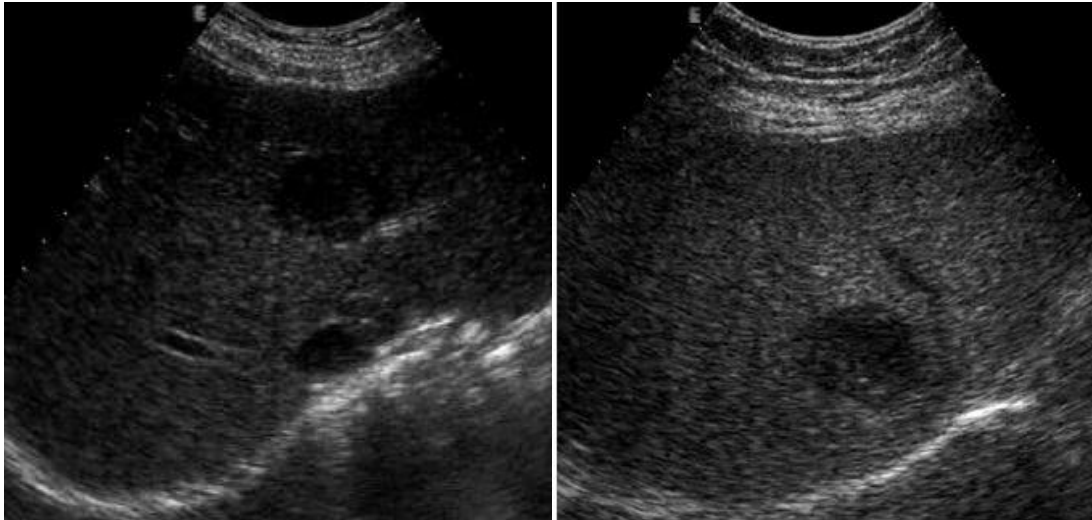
Example of two small sized HCC with hypoechoic sonographic appearance.[13]
